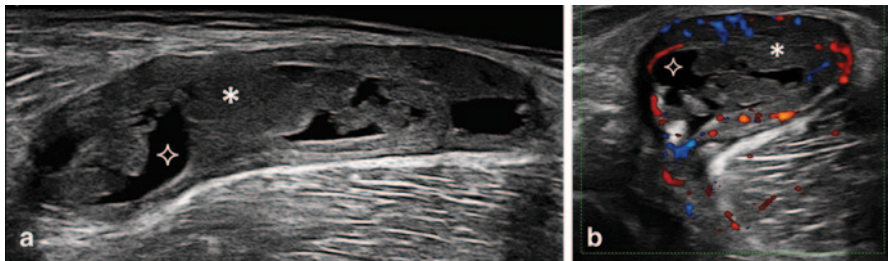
Longitudinal extended (a) and transversal (b) view over a Baker's cyst showing synovial hypertrophy (*asterix*) with Doppler signal and synovial effusion (*star*)
